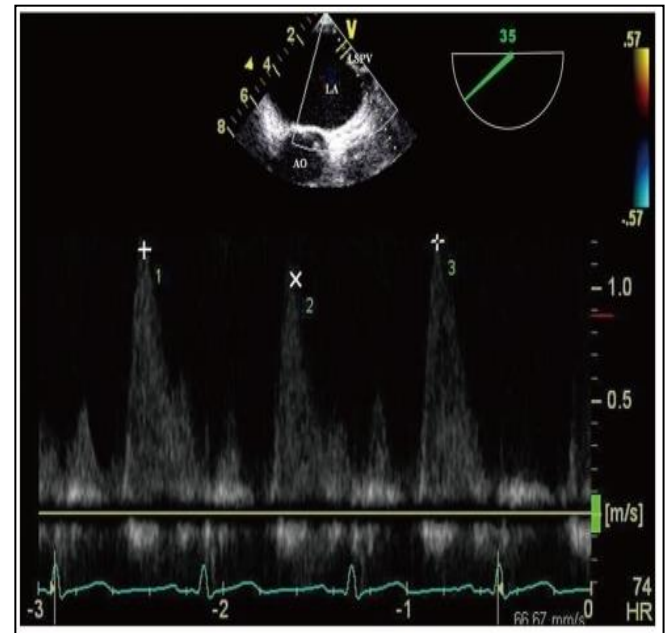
TEE Shows Significant Pulmonary Vein (PV) Stenosis. PW Doppler with PV inflow > 110 cm/s which Confirms Significant Stenosis
